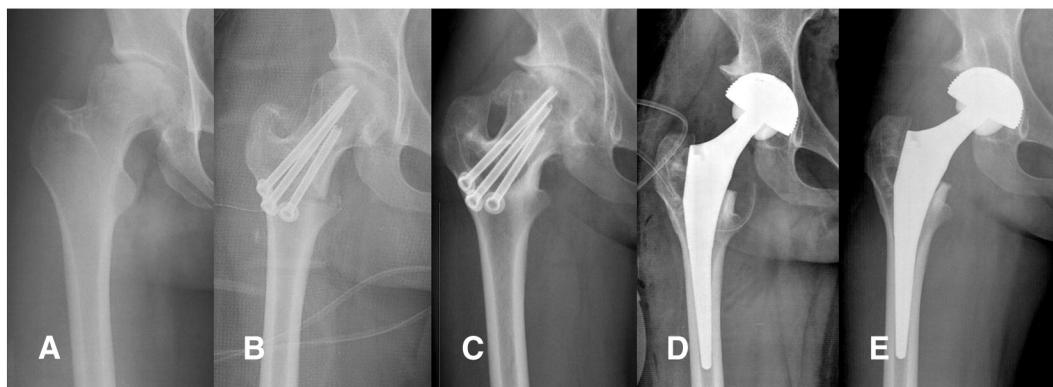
(A) Preoperative radiograph of 20-year-old woman with osteonecrosis of femoral head. (B) Immediate postoperative radiograph after modified transtrochanteric osteotomy and bone graft. (C) Radiograph of 5-year and 6-month follow-up shows osteoarthritic change of her right hip joint. (D) Immediate postoperative radiograph after total hip arthroplasty. (E) Radiograph of 2-year follow-up shows good bone ingrowth without implant position change.
